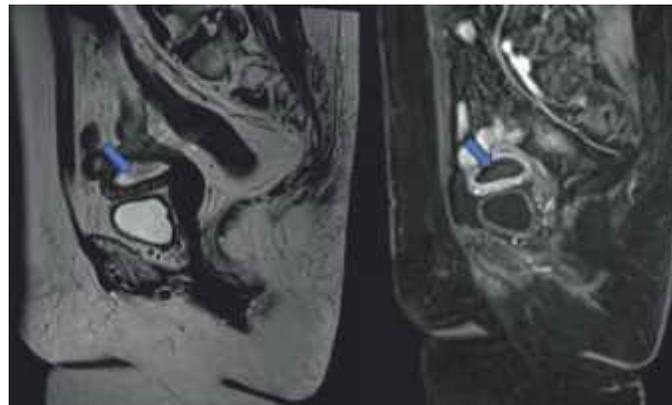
These MRI images of the pelvis – T2WI sagittal (left image) and T1WI post contrast sagittal (right image) the uterus appeared normal in size and was anteflexed due to the compression from the right adnexal mass. The endometrial cavity appeared fluid-filled with a non-enhancing component within (blue arrows)
